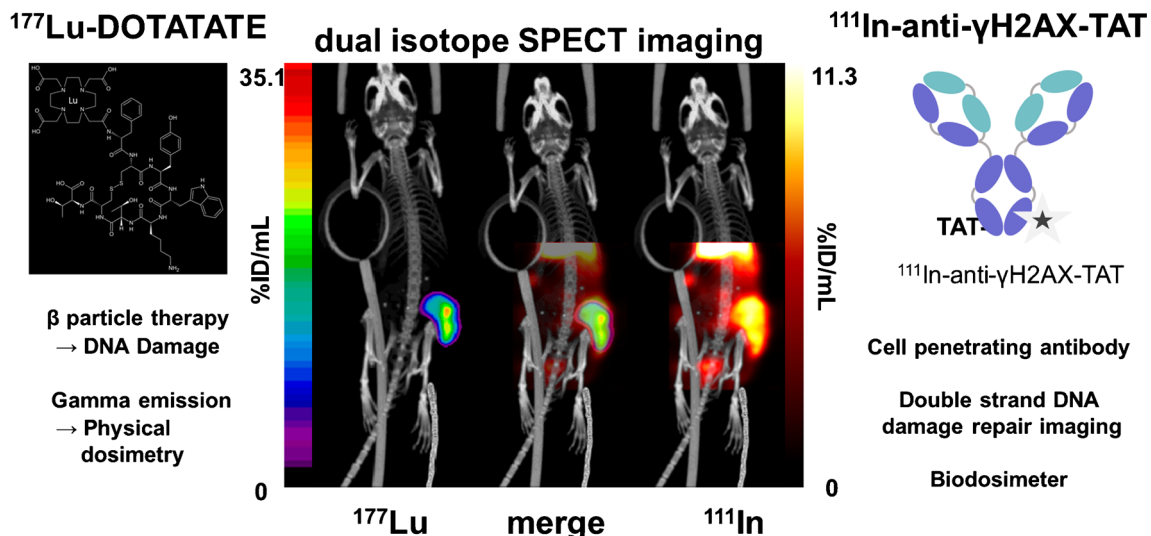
As shown in this figure, the DNA damage generated by [^{177}Lu]DOTATATE therapy can be visualized in vivo using a modified radiolabelled antibody [^{111}In]-anti- γH2AX -TAT. The application of dual isotope SPECT imaging revealed a heterogeneous DNA damage response
